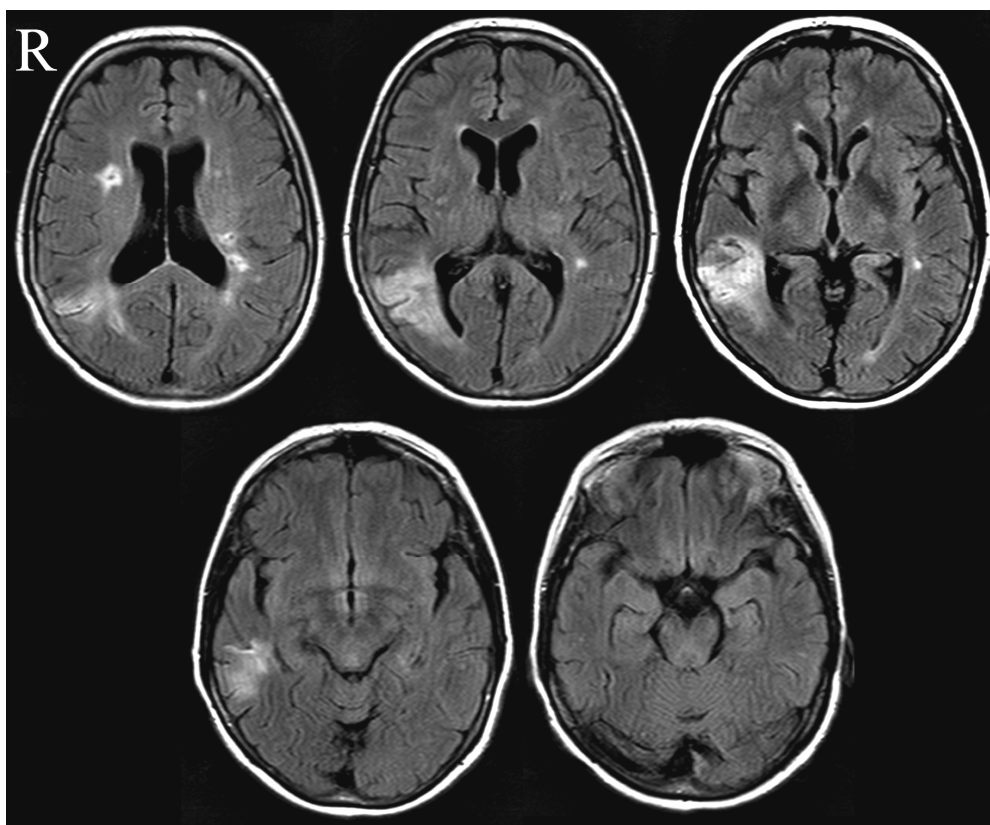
Axial slices of MRI (flare) taken 9 months post-stroke. Left side of the image = Right side of the brain
